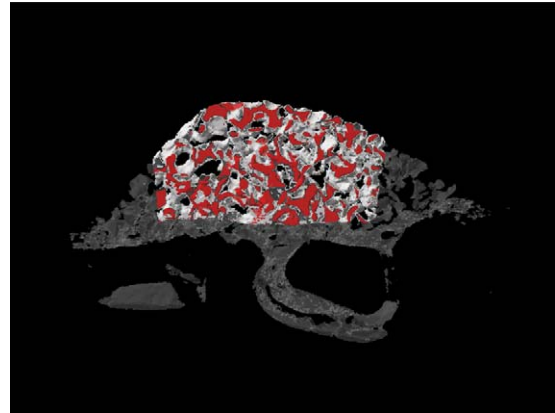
Micro-computed tomographic three-dimensional image build by the Creator software. Once the bony deposits have been identified (red), measurement of the total volume and height of the bone in the sample is feasible.
